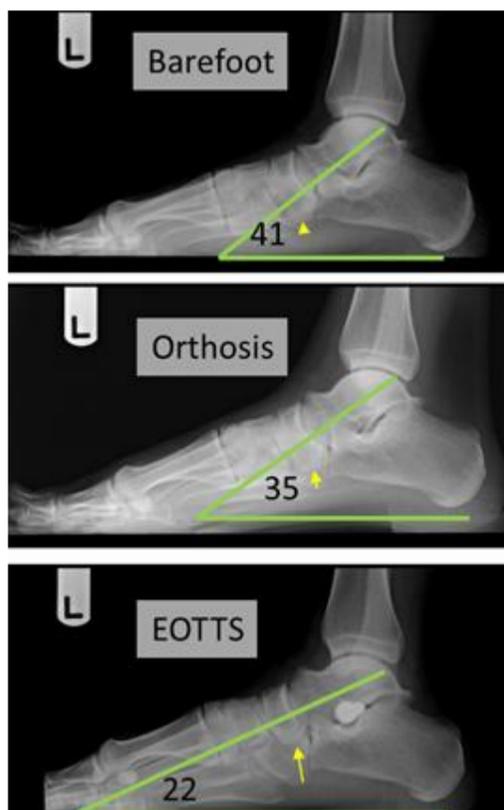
Sample weight-bearing lateral radiographic angle measurement of the talar declination angle (a) barefoot/no intervention (b) with orthosis (c) after extra-osseous talotarsal stabilization (EOTTS).
